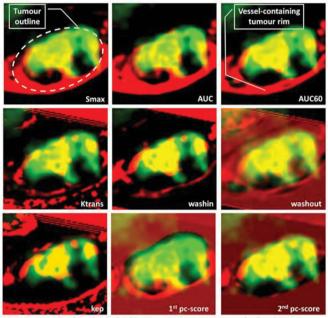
Example of overlap (yellow) between DCE-parameter maps (red) and SPECT peptide uptake (green); AUC = area under the curve, AUC60 = area under the curve fist 60 seconds, Smax = maximum enhancement, pc-score = principal component score
